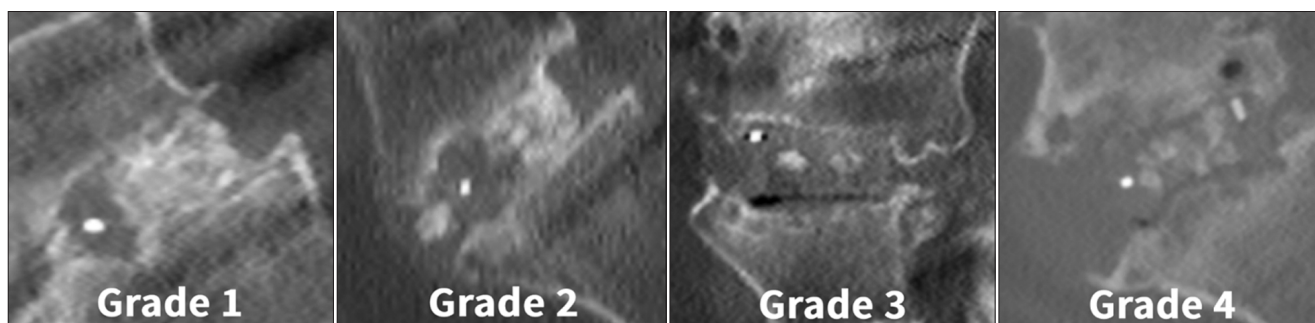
Four-grade system for interbody fusion status using computed tomography scan: grade 1, complete remodeling with trabeculae across the disc space; grade 2, intact graft without lucent lines between endplates and the graft; grade 3, intact graft with a lucent line between endplates and the graft; and grade 4, absence of fusion with resorption of the graft material.
